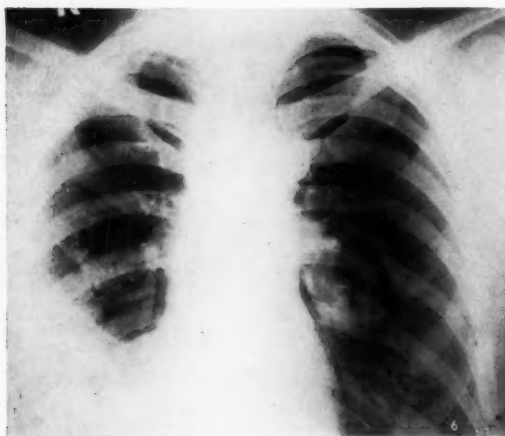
(Case No. 2.) P.A. radiograph of chest.
